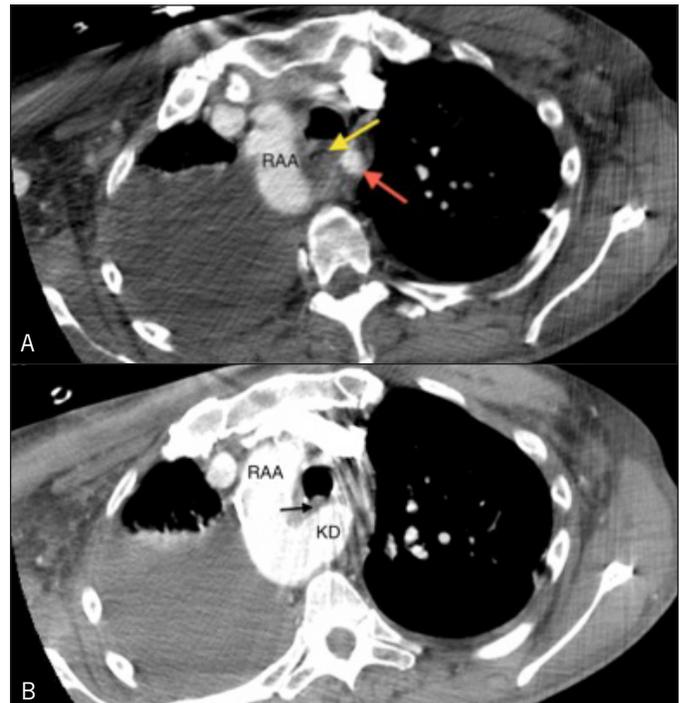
Axial contrast-enhanced chest CT showing (A) right-sided aortic arch, esophageal compression (yellow arrow), and aberrant left subclavian artery (red arrow), and (B) a distal anatomic position to image above showing esophageal compression (black arrow) and Kommerell's diverticulum.
